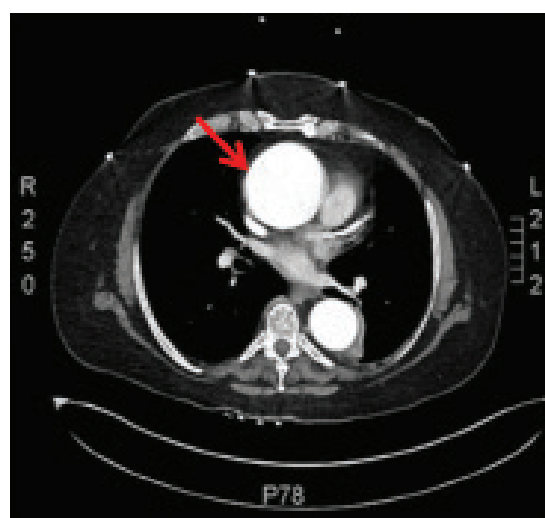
Axial computed tomography (CT) view showing cross-sectional view of the aortic aneurysm.
